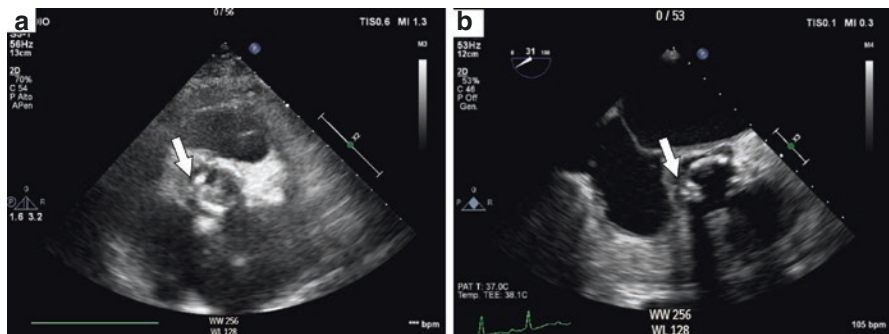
Perivalvular abscess as an echocardiographic finding. Endocarditis-related abscess around aortic valve, visualized as an echogenic space in view of its liquid content. Both images have been obtained from the same patient, adopting transthoracic echocardiogram in (a) and transesophageal echocardiogram in (b)
